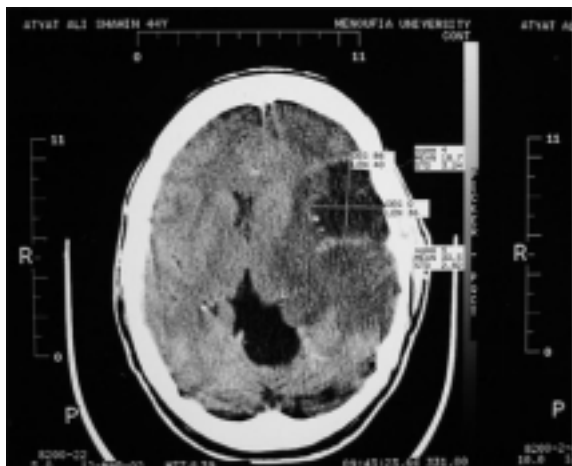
Patient 2, CT scan prior to treatment.
